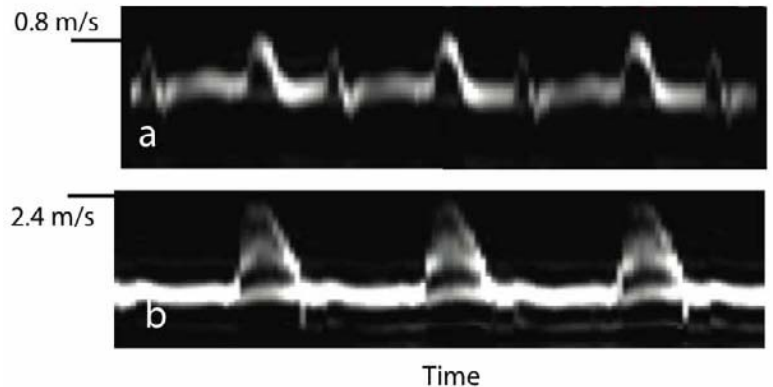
The real-time MR Doppler waveforms demonstrates the typical E and A waves through the mitral (top) valve and elevated aortic valve flow (bottom) on a patient with moderate stenosis.
